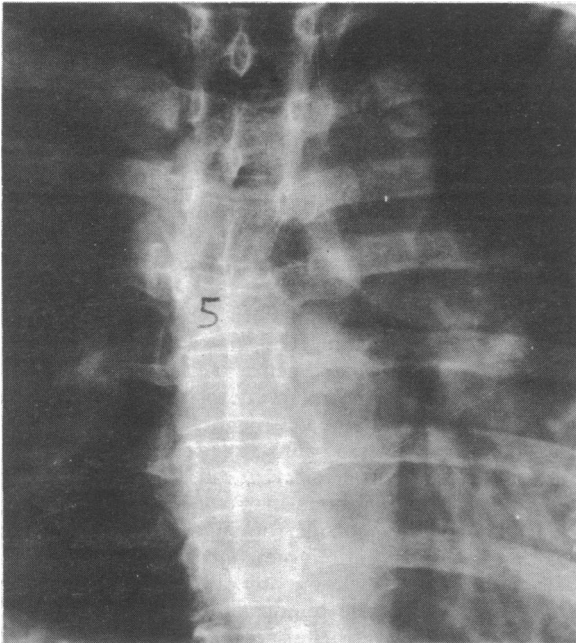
Antero-posterior radiograph showing partial collapse of body of fifth thoracic vertebra, erosion of its left pedicle, and paraspinal abscess. Adjoining disc spaces intact.
